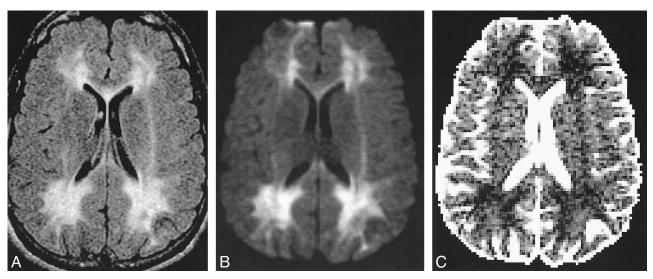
Case 1: a 27-year-old man was screened at birth and was found to have a borderline phenylalanine level. A-C, FLAIR (A), trace diffusion-weighted (B), and ADC_{av} (C) images show extensive white matter abnormalities with restricted diffusion.
